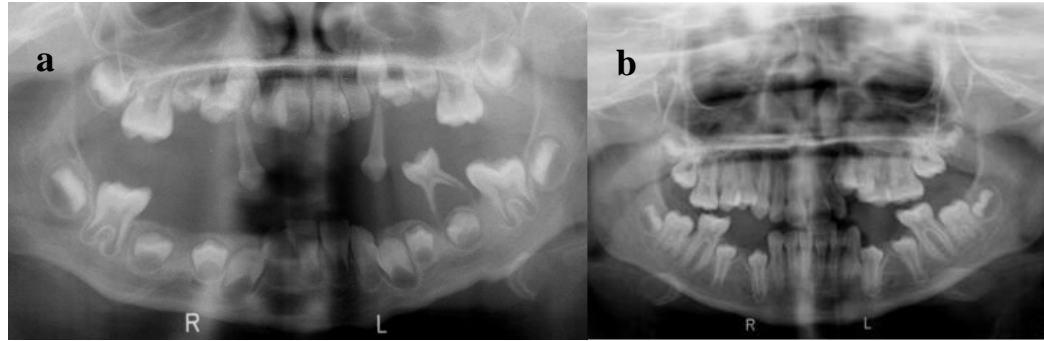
X-ray pictures show the dental symptoms of the older one (Patient I) of the siblings affected by Papillon-Lefèvre syndrome. (a) The first picture was taken in 2006, (b) the second one in 2011.
